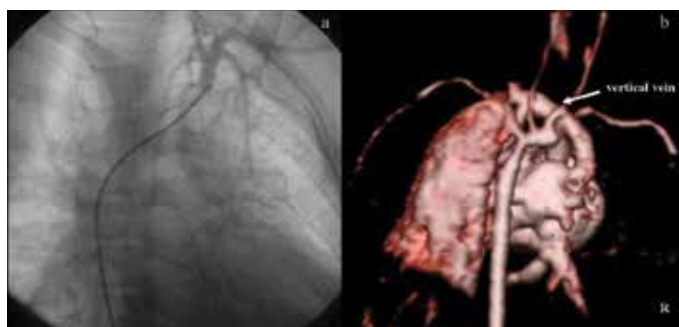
Multiple collateral arteries originating from left subclavian artery on cardiac catheterization (a) and abnormal partially venous return anomaly on the upper-right side of the lung with absence of left lung on cardiac magnetic resonance imaging (b)
